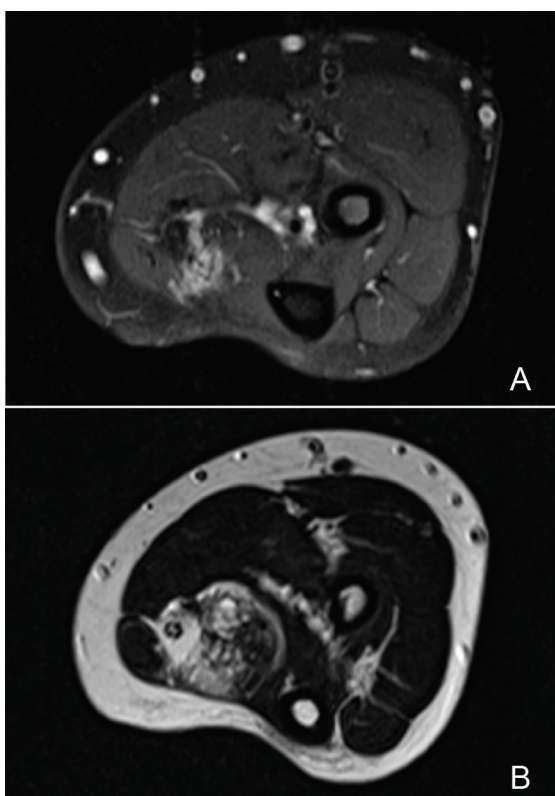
MRI showed intermediate intensely enhancing tortuous soft tissue lesion in deep anterior muscular compartment on medial side of proximal left forearm in T1 (A), high signal tubular structure associated with fatty proliferation and multiple enhancing dilated draining vessels in T2 (B).
